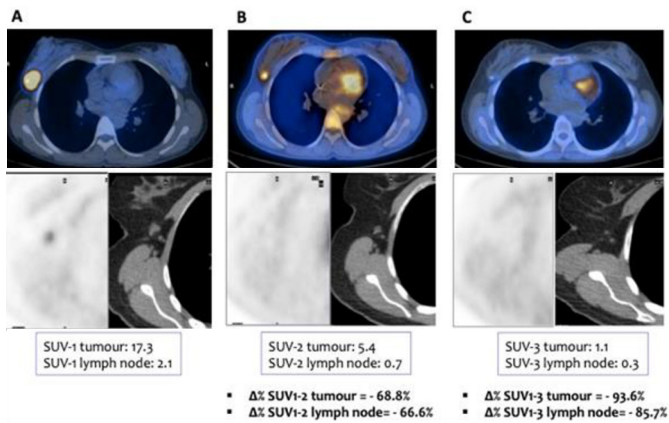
Methodology for the neoadjuvant treatment response, interim and final. (a) Baseline 18F-FDG PET/CT (PET-1), co-registered PET/CT axial slice of mammary lesion, PET and CT of axial slice of axillary lymph node. (b) Interim 18F-FDG PET/CT after 2 cycles of chemotherapy (PET-2) and (c) final treatment 18F-FDG PET/CT (PET-3). In all cases, SUVmax is defined in each location (breast lesion and lymph node), and the calculation of $\Delta\%$ SUVmax is made between the interim and final treatments with respect to basal PET.
